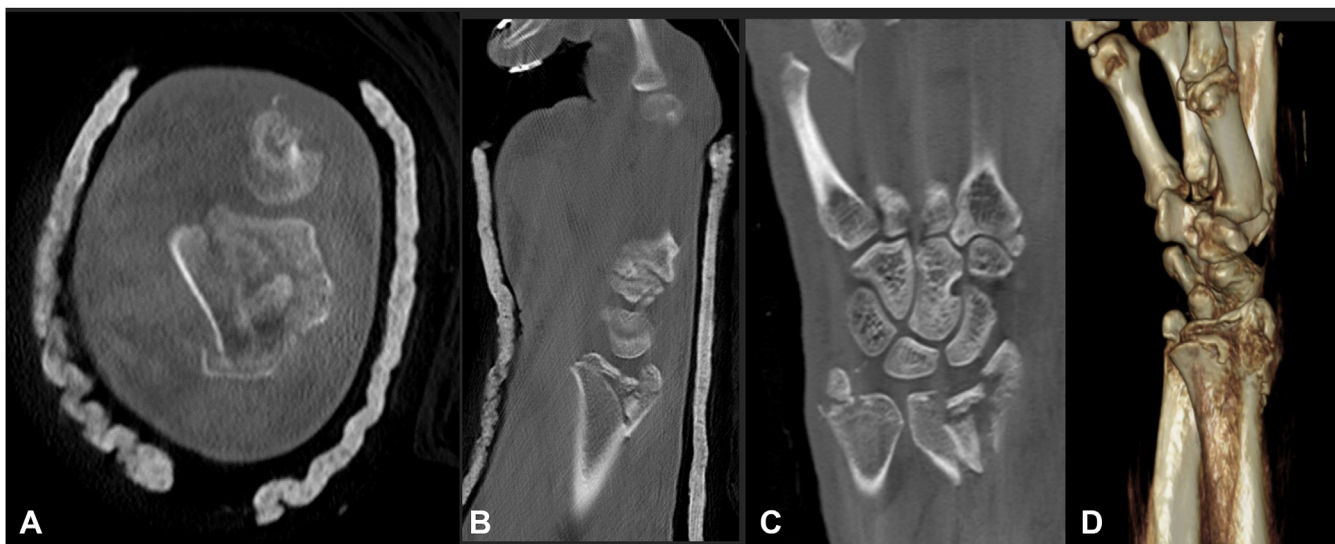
Representative A axial, B sagittal, C coronal, and D 3D reconstruction CT scan images of an intra-articular DRF.
